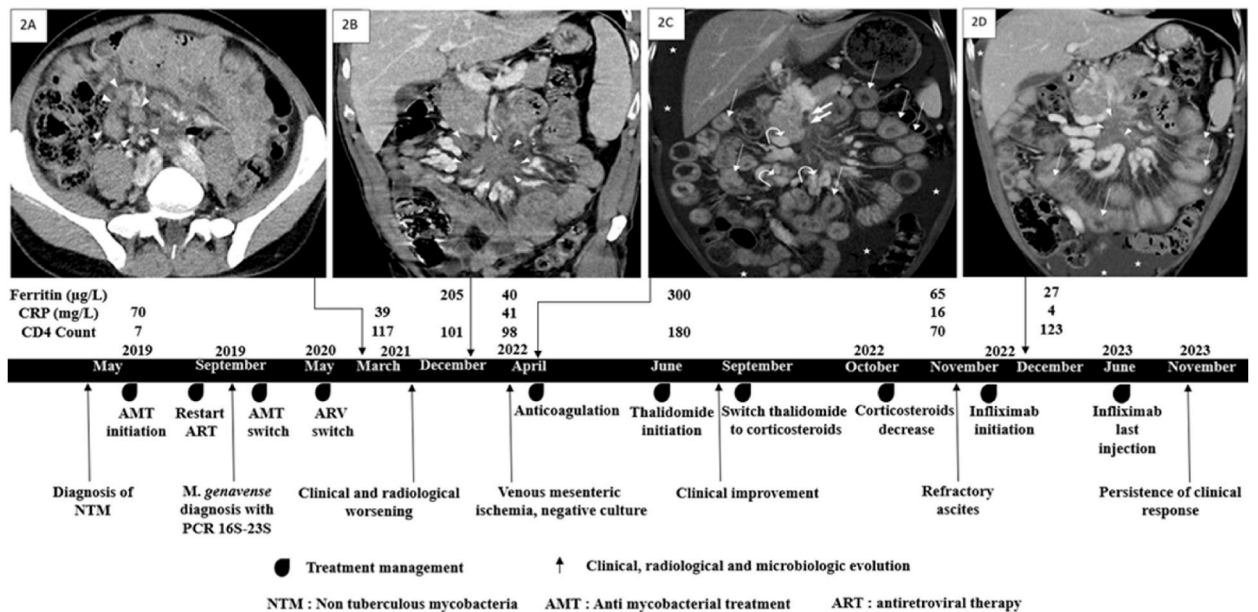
Timeline and images of patient two (2A-2D). CT-scan after (2A-2D) contrast enhancement (Iomeron 350, Bracco Imaging France) at the portal phase. Enlarged mesenteric lymph nodes (arrowheads) in March 2021 (2A). In December 2021, mesenteric lymph nodes gathered in a soft tissue density mass (arrowheads) (2B). In April 2022, views showed mesenteric ischemia secondary to superior mesenteric vein thrombosis due to the enlarged mesenteric lymph nodes compression with filling defect in the superior mesenteric vein (thick arrows), varices (rounded arrows), ascites (stars), mesenteric congestion, bowel thickened (8–9 mm), target sign and hyperenhancement (thin arrows) (2C). In December 2022, these signs appear less marked after three months of infliximab, with, in particular, a decrease in the thrombosis of the superior mesenteric vein and ascites (stars) (2D).
